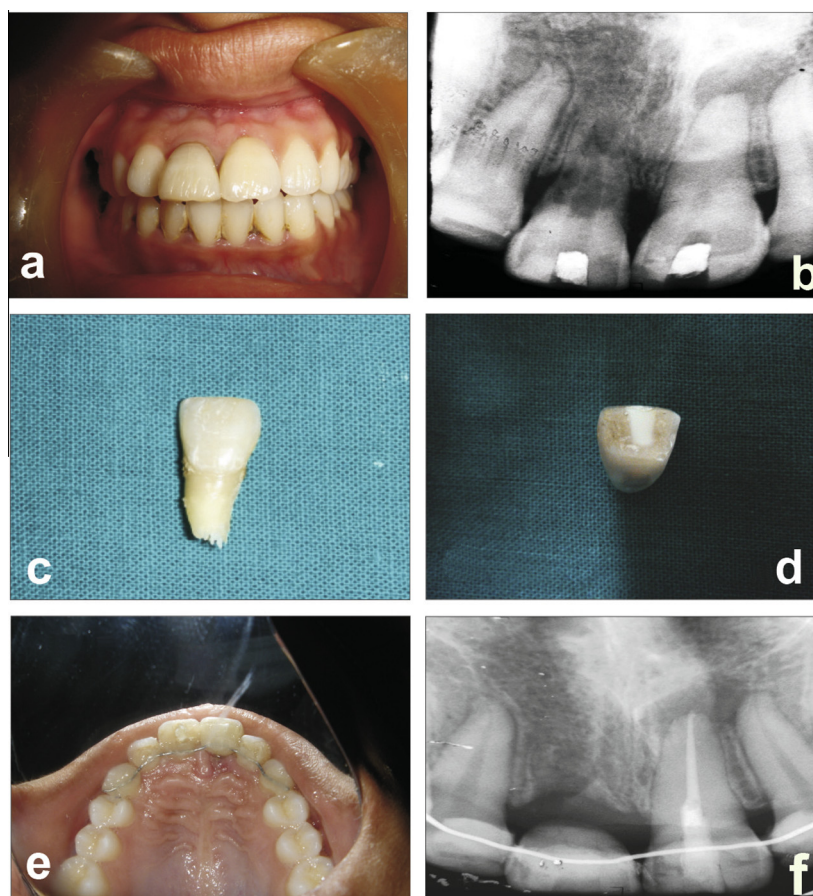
(a) Preoperative clinical view; (b) preoperative radiograph; (c) extracted maxillary right central incisor; (d) natural tooth pontic shaped; (e) provisional splinting of the natural tooth pontic; and (f) radiograph after splinting pontic to adjacent endodontically treated central incisor.
